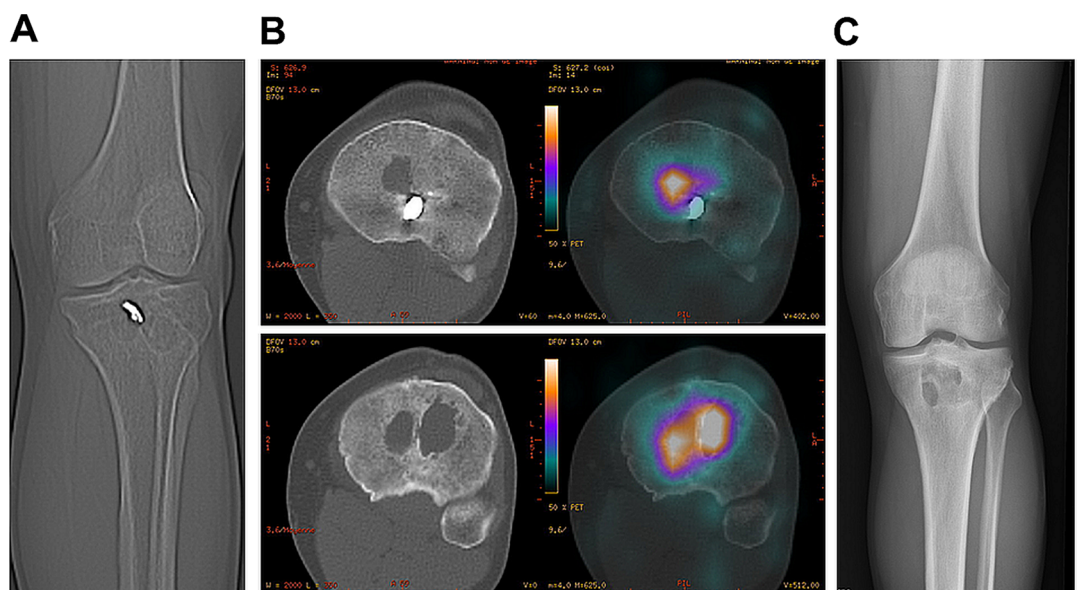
(A) X-ray of the tibia showing the foreign body and the bone lysis. (B) CT scan combined with granulocyte-labelled scintigraphy showing a recruitment of polymorphonuclear cells within the bone lysis. (C) X-ray of the tibia 3 years after the treatment.
